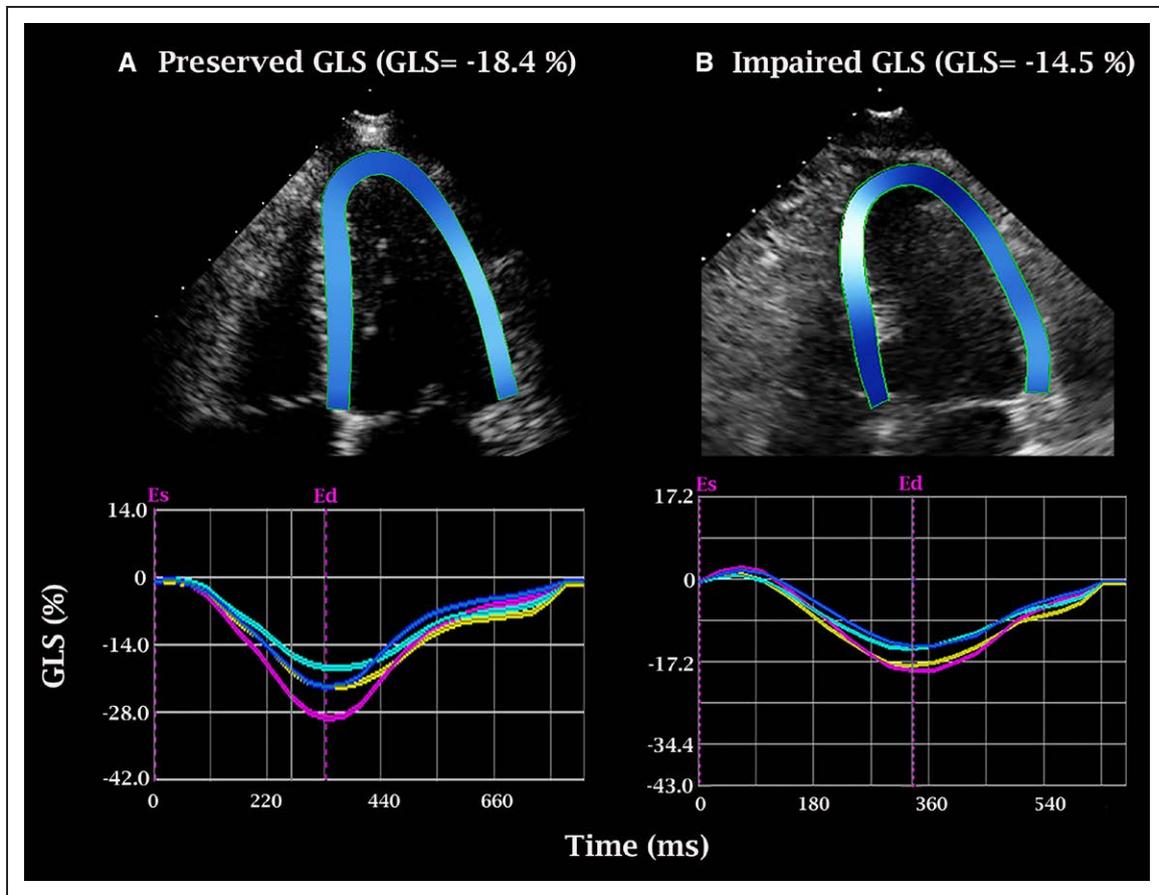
Representative global longitudinal strain (GLS) images in apical 4 chamber views. Representative GLS images in apical 4-chamber views were shown; (A) normal GLS (−18.4%); a 62-year-old woman with moderate aortic stenosis (AS) and left ventricular ejection fraction (LVEF) is 69%; (B) impaired GLS (−14.5%); a 60-year-old woman with moderate AS and LVEF is 63%. Ed indicates end-diastole; and Es, end-systole.
